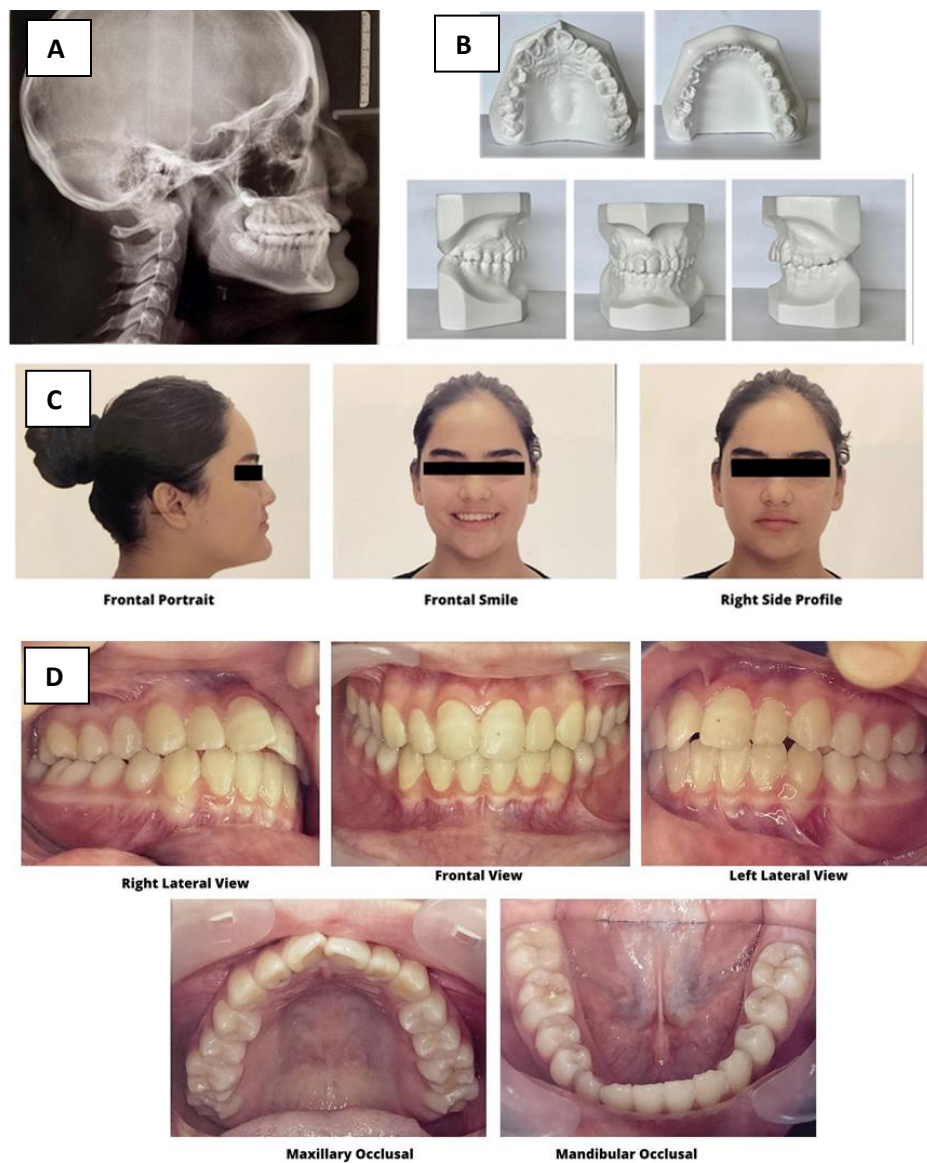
Pre-treatment (A) cephalometric radiograph, (B) diagnostic casts, (C) extraoral radiographs, (D) intraoral radiographs.
